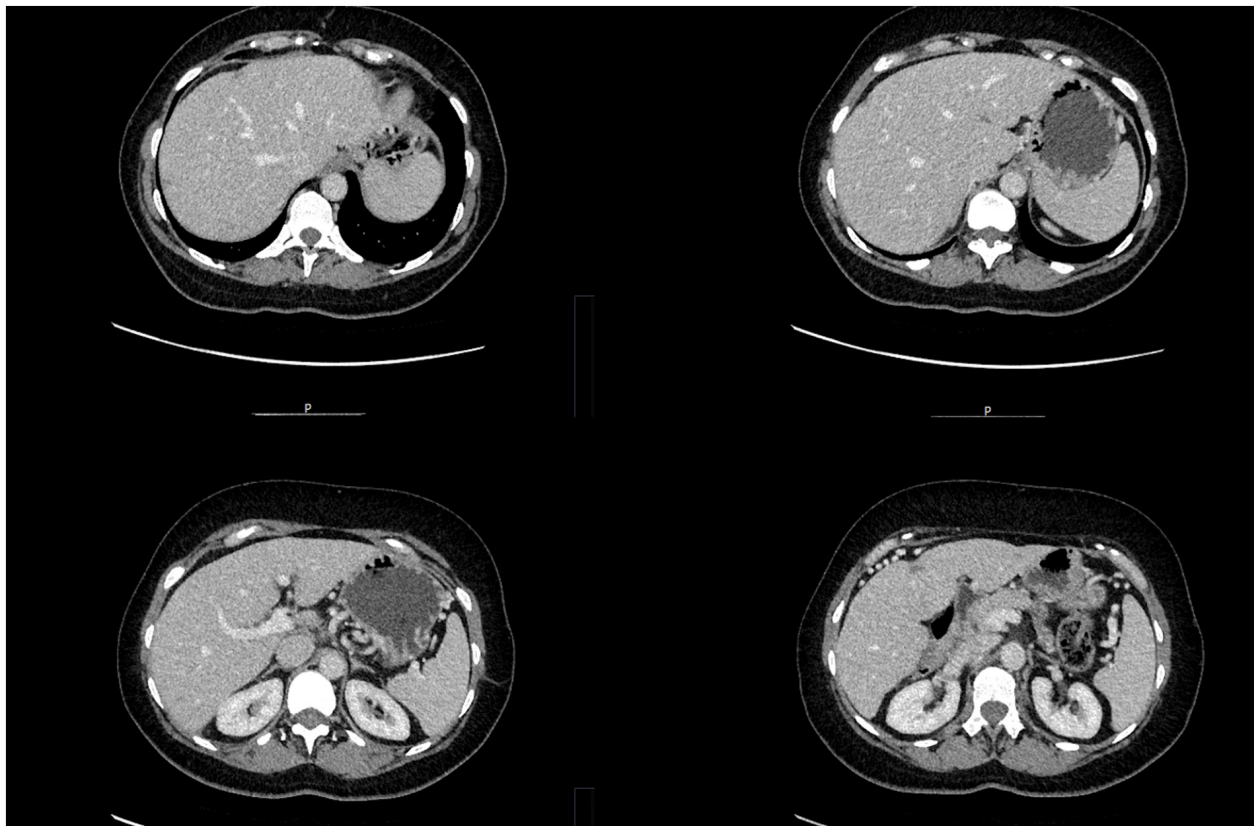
Disease response. CT following 6 months of chemotherapy (April 2019) shows regression of the primary pancreatic body tumour and no radiologically detectable liver lesions.
